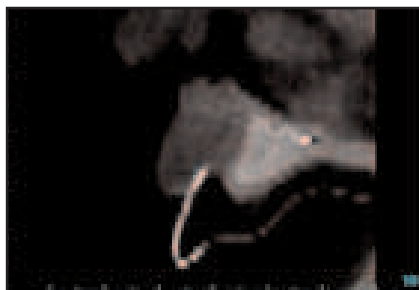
Image obtained from the CT scan, with the stent outlined in radiopaque material.
